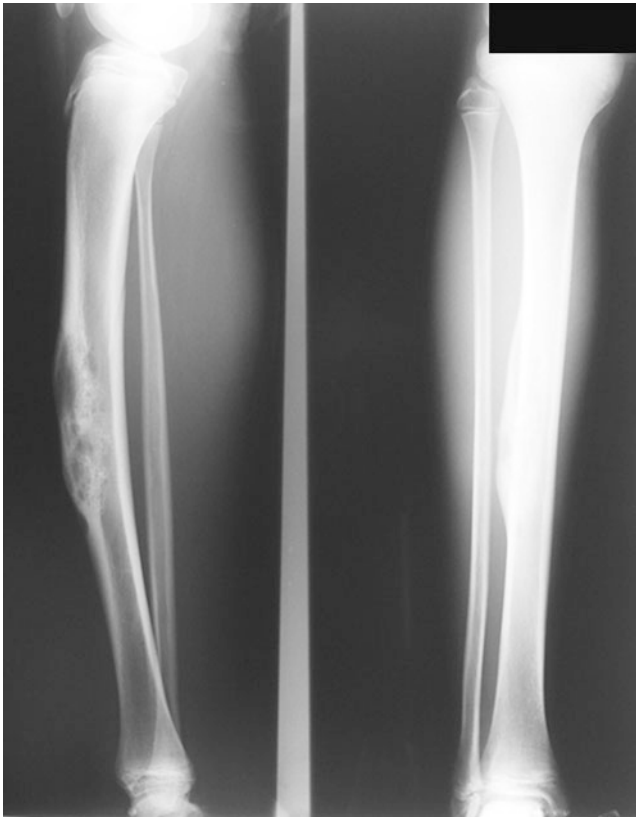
AP and Lat radiographs of the tibia showing diaphyseal lesion located eccentrically
